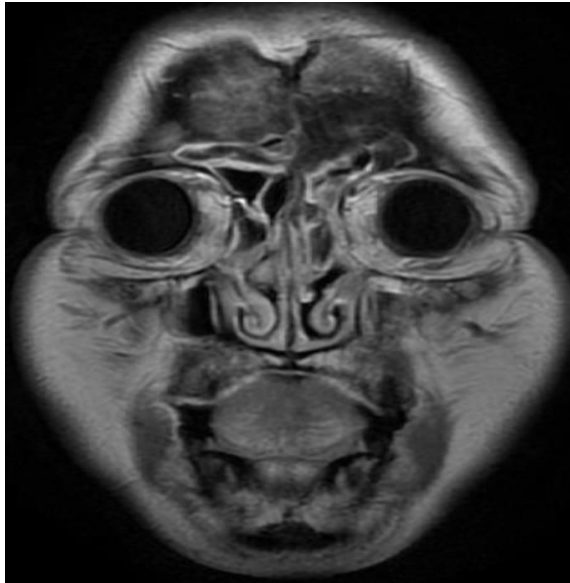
In coronal MRI, an incomplete local bone structure of the right frontal bone, local thickening of the subdural, and a visible enhancement in enhanced scanning are seen. The mucosa of the bilateral frontal sinus, ethmoid sinus, maxillary sinus, and sphenoid sinus were thickened, with equal T1 long and T2 signals.
